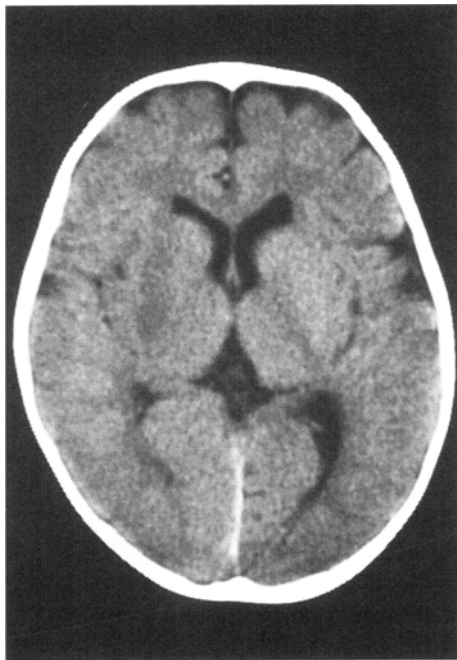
CT scan of the brain showing a fresh cerebral infarction in the area from the right posterior limb of the internal capsule to the corona radiata.
